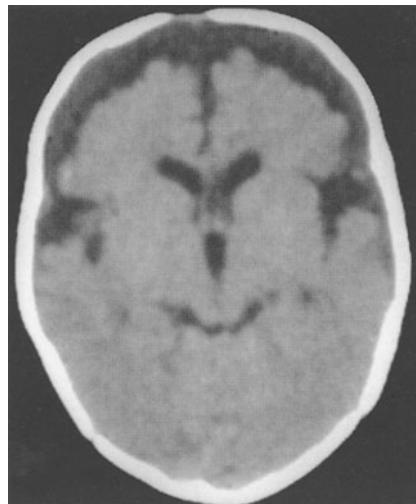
A 4-month-old boy with acute dehydration. CT scan shows two pericerebral compartments: a dense subdural effusion and an isodense subarachnoid effusion
